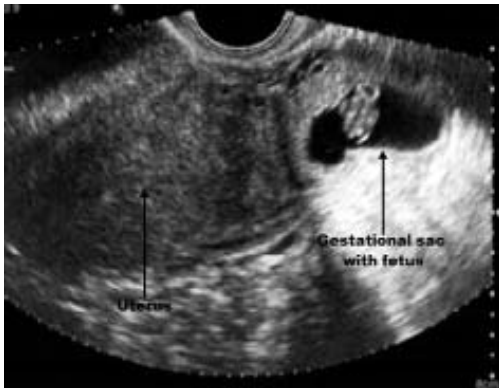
Transvaginal ultrasonography showing right tubal gestational sac involving fetus with a gestational age of 7 weeks and 6 days (crown-rump length of the fetus was 14 mm)
